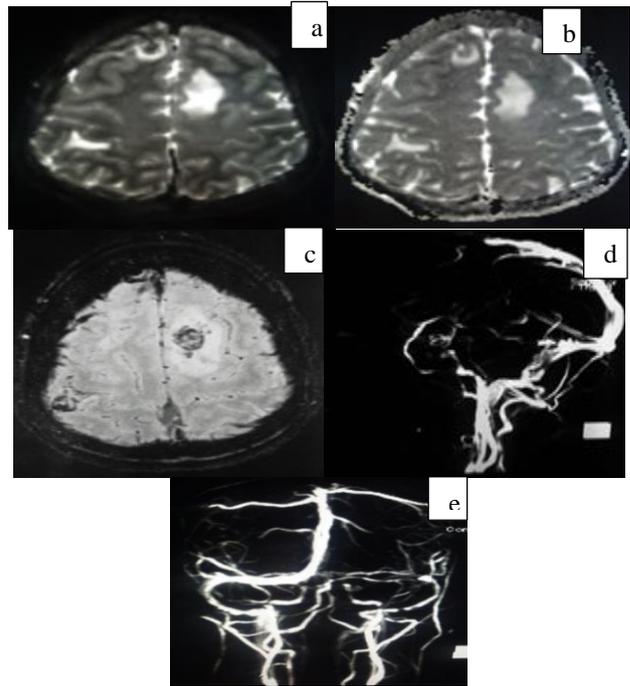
b and c: DWI images shows hyperintensities in bilateral frontal lobes, ADC confirms no restriction. SWI shows blooming within the concerned areas and confirms it to be hemorrhages; (d) and (e): MRV shows non visualization of anterior part of superior saggital sinus and hypoplastic left transverse sinus.
